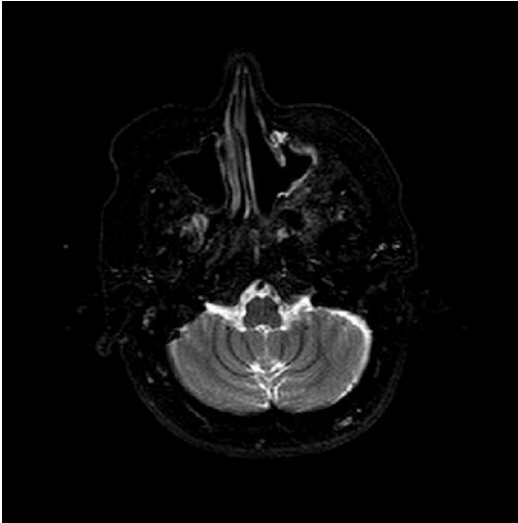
Axial postoperative MRI scan showing an area of high signal in the patient's left maxillary antrum, indicating the need for a biopsy to be performed
